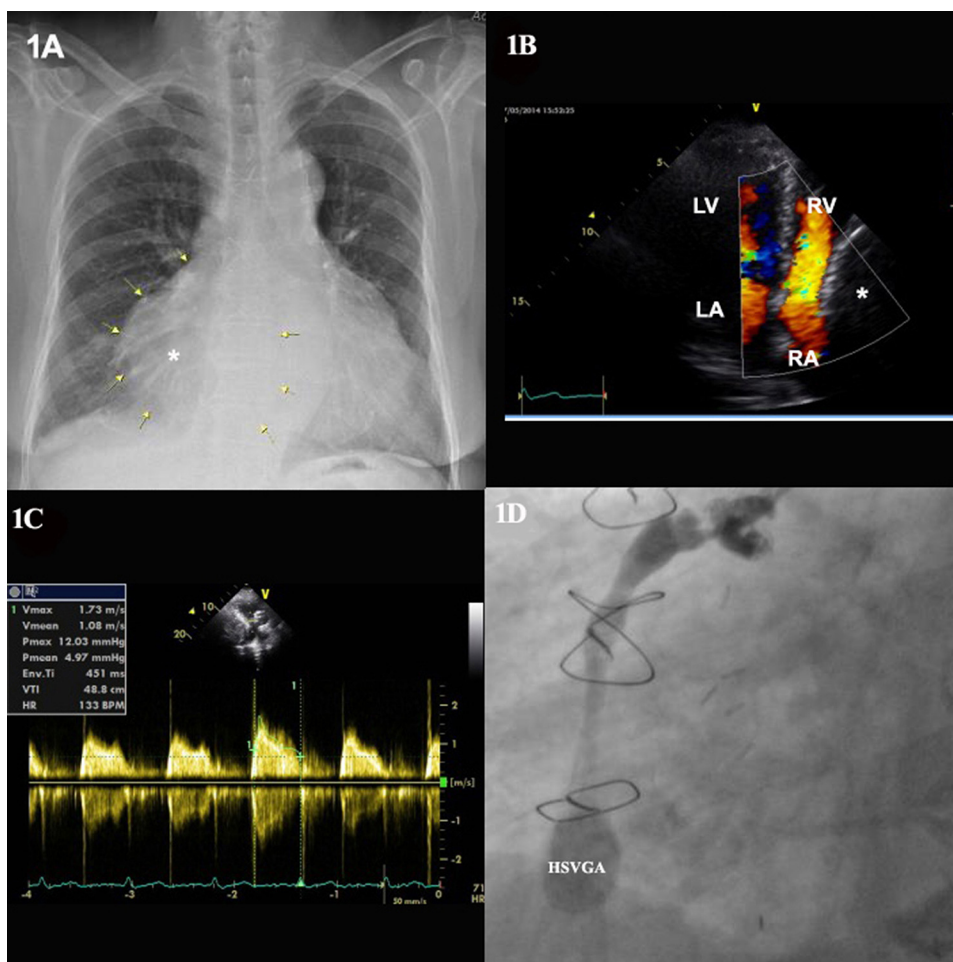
A mass abutting the right mediastinal contour on chest X-ray (Panel A). Transthoracic echocardiography images of mass compressing the right atrium and ventricle (Panel B). An extracardiac mass was causing a significant stenosis with a peak/mean gradient pressure of 12.3/4.97 mmHg on tricuspid valve (Panel C). Selective coronary angiogram images of HSVGA in right oblique projection (Panel D). * HSVGA. HSVGA: huge saphenous vein graft aneurysm; RA: right atrium; RV: right ventricle; LA: left atrium; LV: left ventricle.
